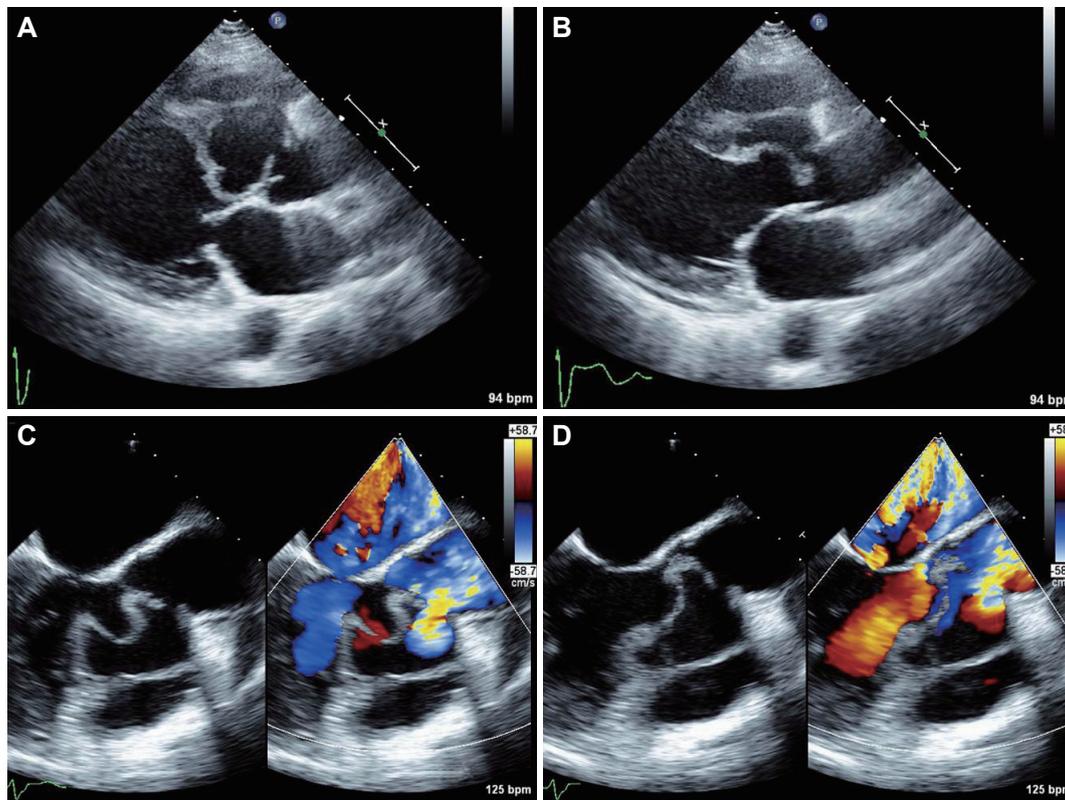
Echocardiographic findings of SVA with interventricular dissection. Parasternal long axis view in TTE showing various sizes and appearances; increased size during diastole (A), decreased size during systole (B). Short axis view in TEE shows inflow from aortic root to SVA during diastole (C) and outflow during systole (D). SVA: sinus of Valsalva aneurysm, TTE: transthoracic echocardiography, TEE: transesophageal echocardiography.
